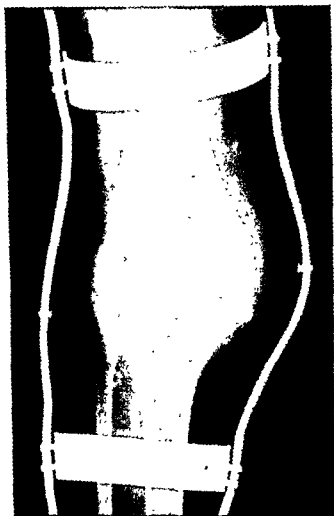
Case #8376 (age, 43) Same patient as in Figure 14 X-ray control of correction of marked valgus deformity from advanced hemophilic arthropathy of left knee in hemophilia Hesselig brace constructed without knee joint
